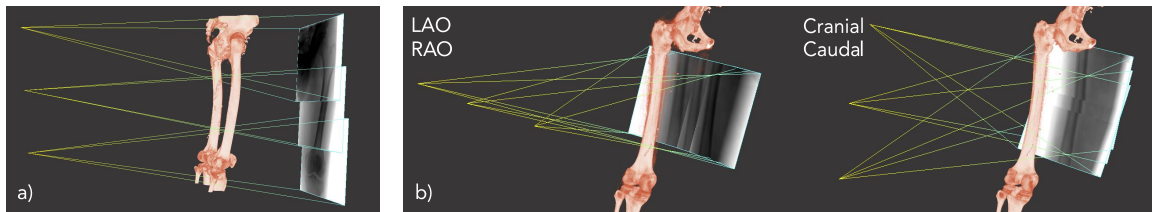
a) Each training instance comprises three X-ray images. b) The training X-ray images are generated in the LAO/RAO and Cranial/Caudal directions.
